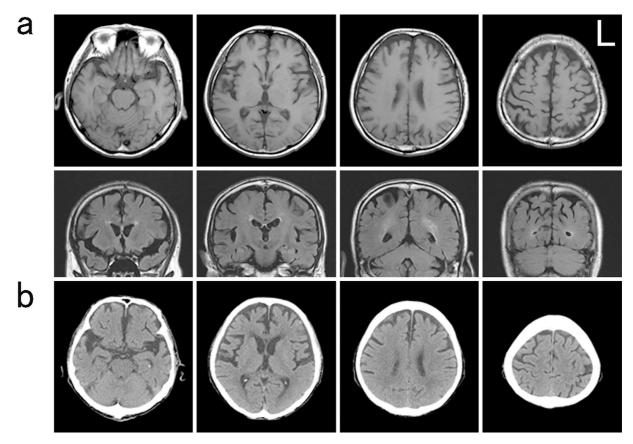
Brain MRI and CT images of the patient. a: MRI T1-weighted axial (upper) and fluidattenuated inversion recovery (FLAIR) coronal (lower) images obtained two years after onset revealed slight atrophy of the bilateral superior parietal lobule, b: Brain CT images obtained seven years after onset showed bilateral atrophy of the frontal lobe with enlargement of the anterior horn of the lateral ventricles and Sylvian fissures.
